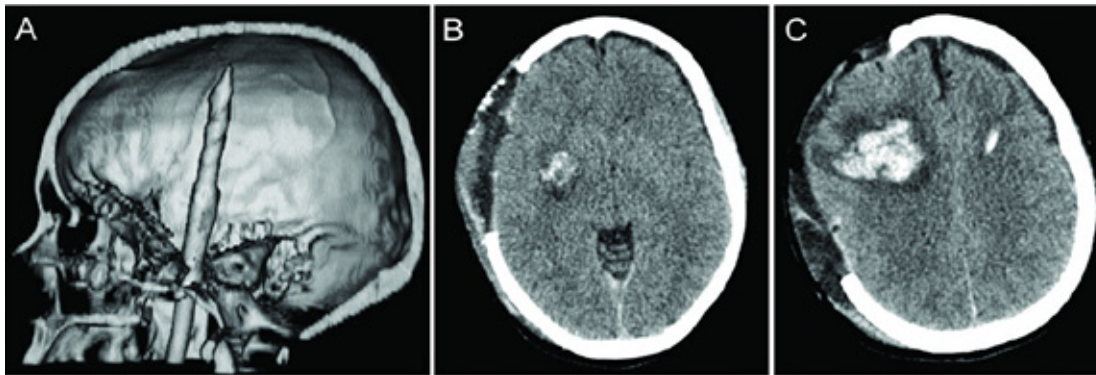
Preoperative 3D reconstruction (A) showing craniocerebral penetrating injury caused by the shaft of a spear gun. Note the entry point through the cranial base towards coronal suture. Postoperative sequential (B, C) CT scans demonstrating acute traumatic insular (B) and opercular contusions (C) on the right side throughout missile trajectory.
